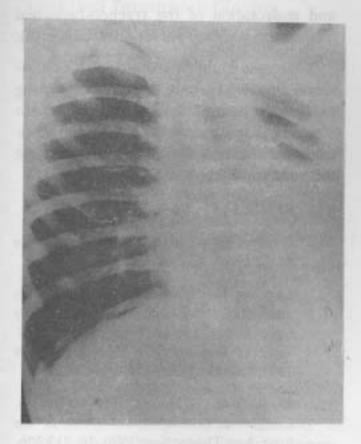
Chest roentgenogram showing an opaque left hemithorax with ipsilateral shift of the mediastinum and hemiated right lung.
